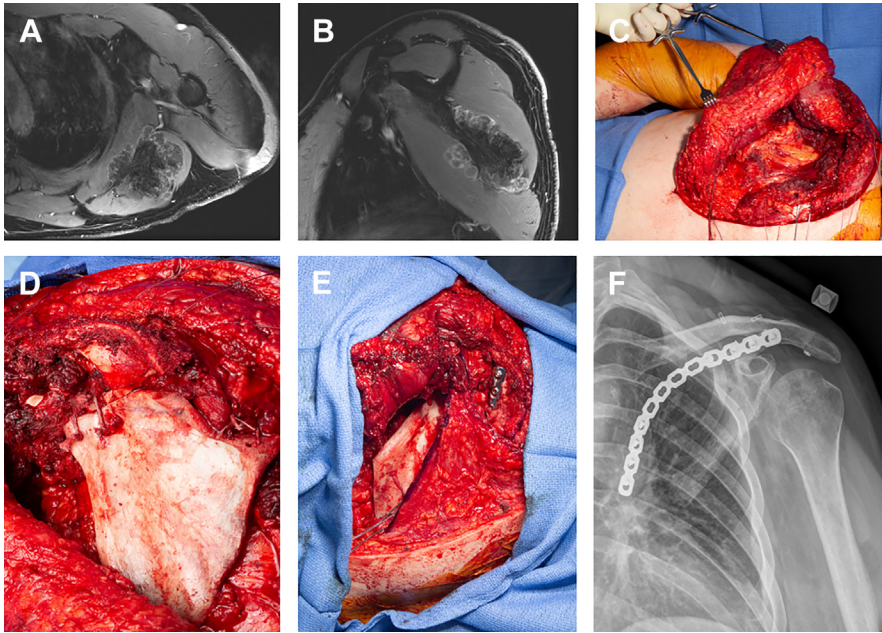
Axial (A) and sagittal (B) MRI with contrast showing a secondary chondrosarcoma involving the inferior aspect of the scapula. The patient underwent a partial scapulectomy from a posterior approach (C). The scapula was reconstructed with an allograft (D) and soft-tissue reconstruction was performed with a lower trapezial (E) transfer with healing of allograft (F) at most recent follow-up.
